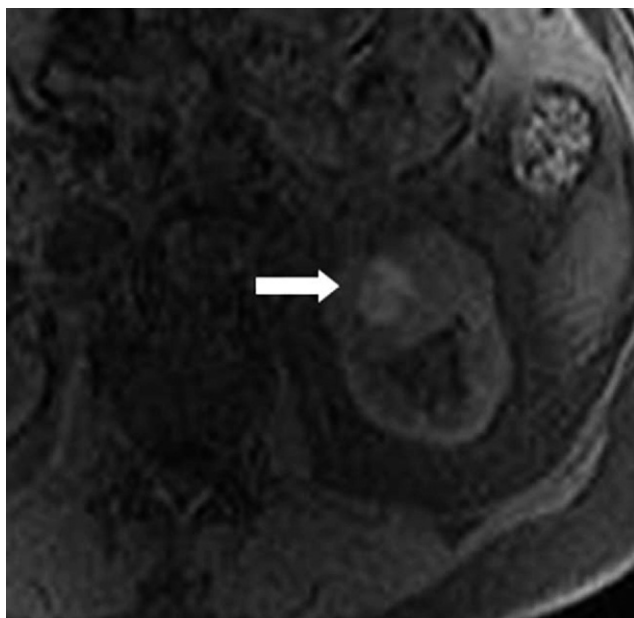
Sporadic papillary RCC. Axial precontrast, fat-suppressed, T1-weighted MRI shows hyperintense signal (arrow) within the left papillary RCC, suggesting hemorrhage.
